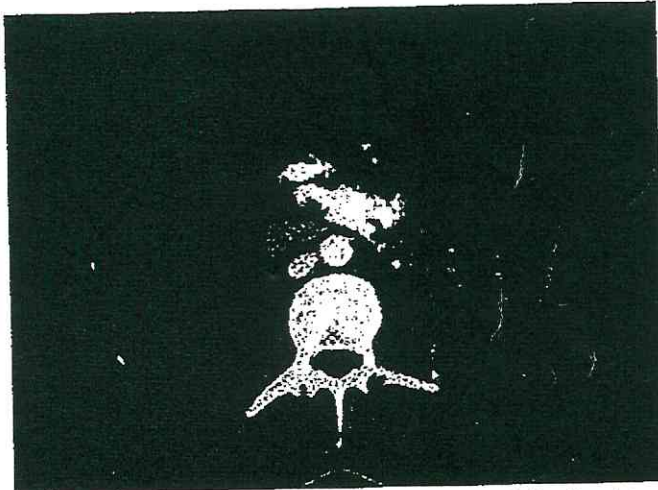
During the arterial phase assessment following intravenous contrast injection, the abdominal CT scan reveals contrast material extravasation arising from ruptured pseudoaneurysm within the large hematoma located in the mesentery.
